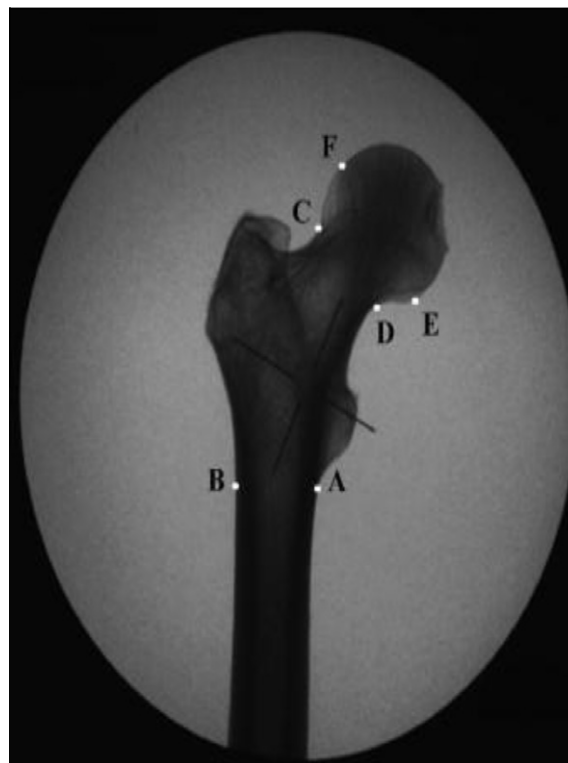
Landmarks selected on the radiograph of the proximal femoral epiphysis⁷: Quoted from: Kranioti E, Vorniotakis N, Galiatsou C, İşcan M, Michalodimitrakis M. Sex identification and software development using digital femoral head radiographs. *Forensic Sci Int* 2009;189(1):113.e1–113.e7⁷.
